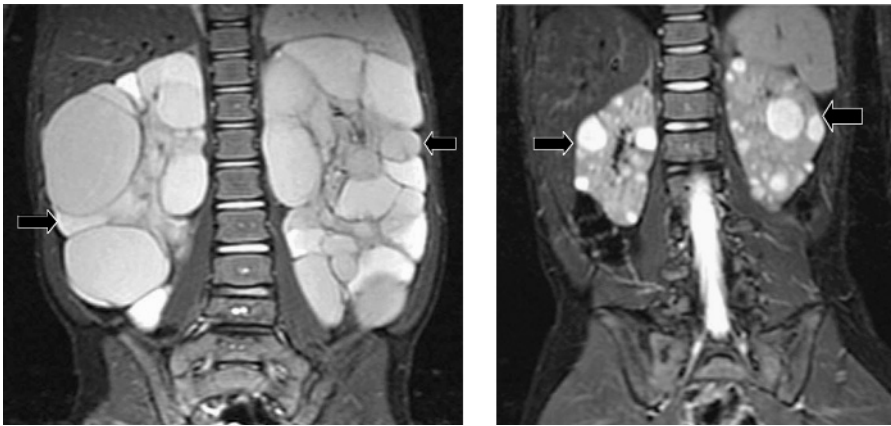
Polycystic kidney disease versus multiple simple renal cysts. T₂-weighted magnetic resonance images from patients with tuberous sclerosis complex. The image on the left shows massively enlarged kidneys with virtually complete replacement of renal parenchyma by cysts; the image on the right shows that multiple but much smaller cysts are present, with intervening normal parenchyma.
